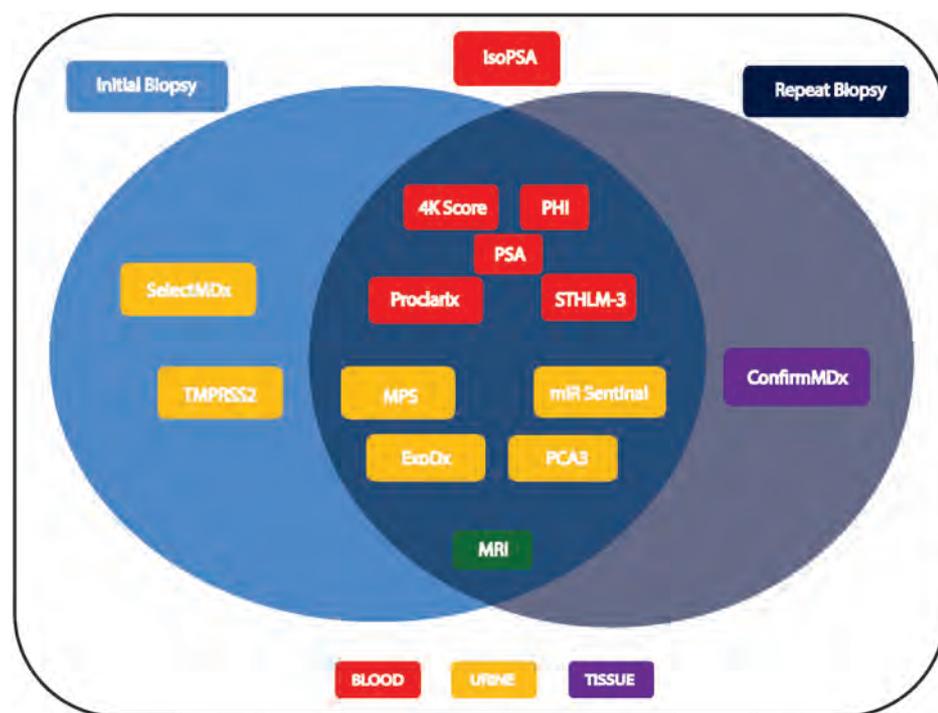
Biomarker and imaging tests in the initial and repeat prostate biopsy settings. MPS indicates MyProstateScore; MRI, magnetic resonance imaging; PHI, Prostate Health Index; PSA, prostate-specific antigen.
